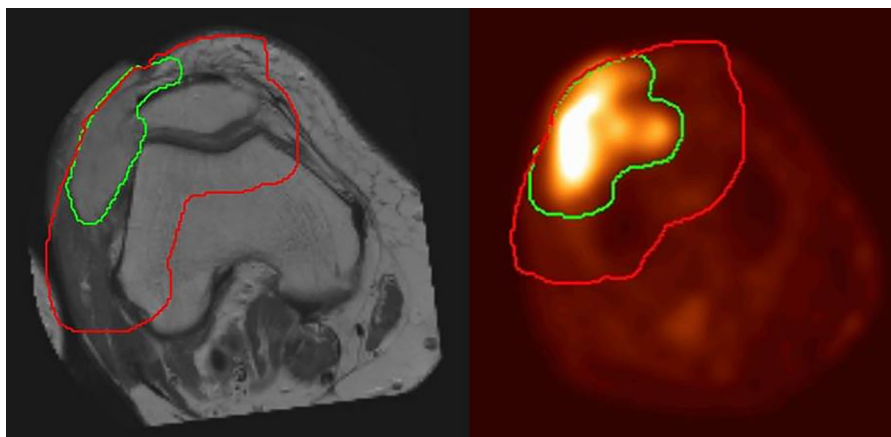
Delineation of a soft tissue sarcoma of the knee. In green the gross tumor volume and in red the planning target volume. On the left: a MRI scan fused to the radiotherapy planning CT-scan is shown, while on the right the FDG PET-CT scan is used for the delineation
